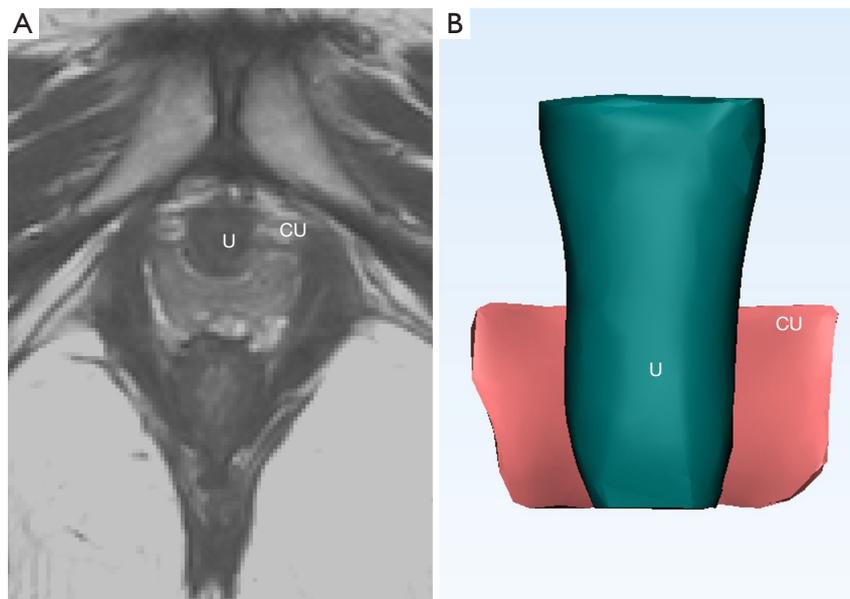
3D reconstructions of the compressor urethrae and urethra. (A) The axial 2D magnetic resonance image. (B) 3D models of the compressor urethrae and urethra. 3D, three-dimensional; 2D, two-dimensional; CU, compressor urethrae; U, urethra.
